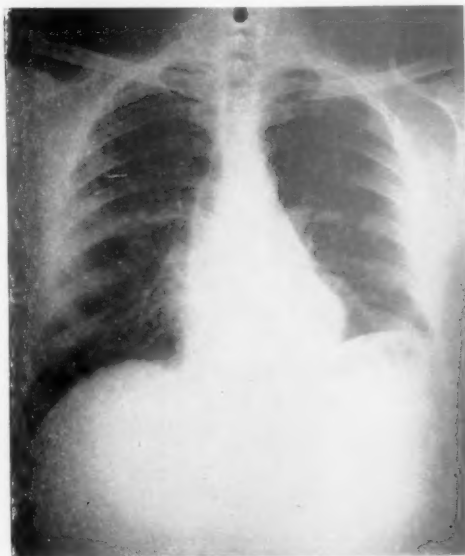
Subsequent x-rays of patient shown in Fig. 3A. Patient was cured by bronchoscopy and postural drainage without surgery.
